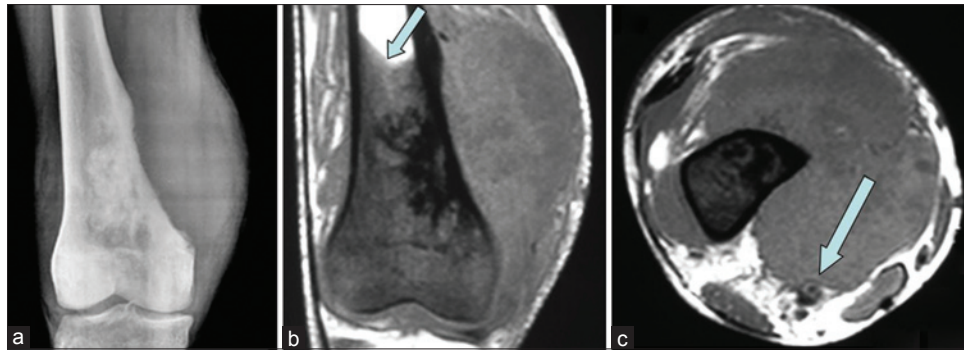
Osteosarcoma in the distal end of femur: (a) X-ray thigh with knee anteroposterior view showing big soft tissue component on the medial side; (b) MRI-coronal section showing the medullary extent (arrow); (c) MRI-axial section showing the proximity of the popliteal vessels
